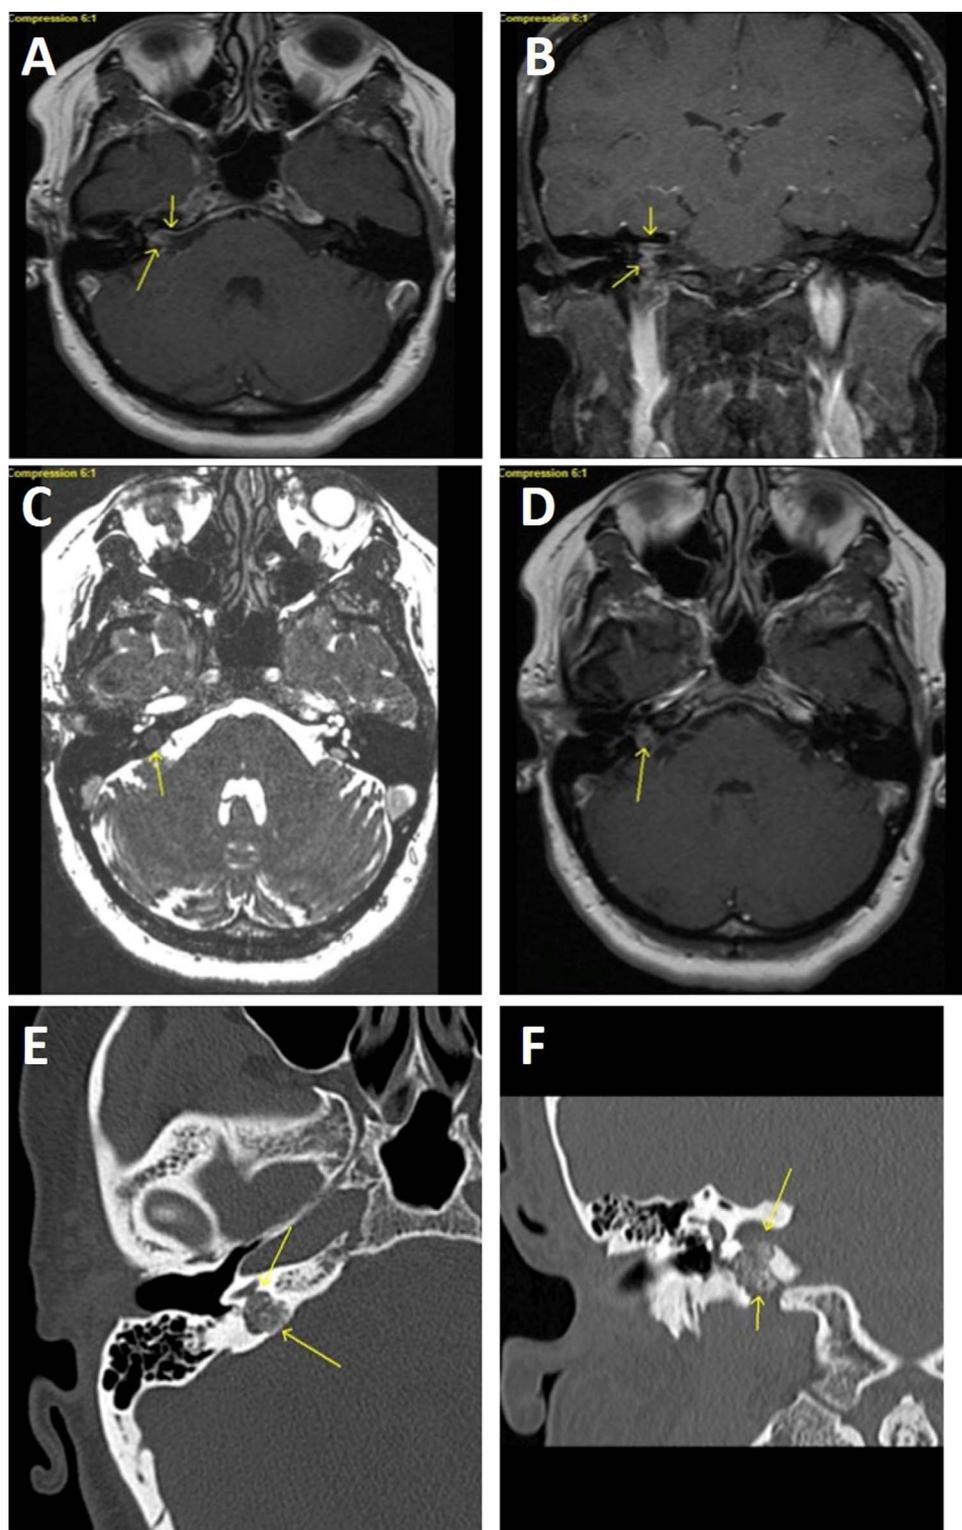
A: Axial T1 post-contrast image demonstrates linear enhancement along the walls of the right internal auditory canal (arrows). B: Coronal T1 post-contrast image demonstrates linear enhancement along the walls of the right internal auditory canal contiguous with an enhancing lesion just inferiorly in the right petrous apex (arrows). C: Axial FIESTA T2-weighted sequence demonstrates a faintly hyperintense lesion in the right petrous apex adjacent to the basal turn of the cochlea (arrow). D: Axial T1 post-contrast image demonstrates enhancement within the lesion (arrow). E: Axial temporal bone CT image demonstrates a circumscribed lucent lesion with calcified internal matrix in the right petrous apex adjacent to the basal turn of the cochlea (arrow). F: Coronal temporal bone CT image demonstrates the lucent lesion with internal calcified matrix extending from the inferior aspect of the right internal auditory canal down to the pars nervosa of the right jugular bulb (arrows).
